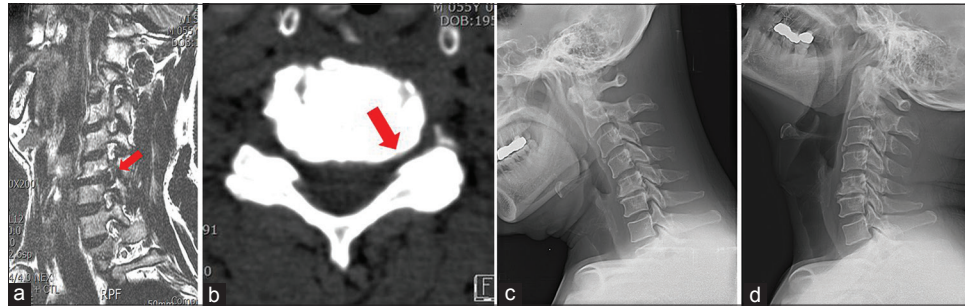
(a) The magnetic resonance imaging showed a herniated intervertebral disc (arrow), foraminal stenosis at C5-6 left. (b) The computed tomography showed a foraminal stenosis (arrow) at C5-6 left. (c) The flexion view, (d) The extension view showed disc space narrowing and bony spur at C5-6.
